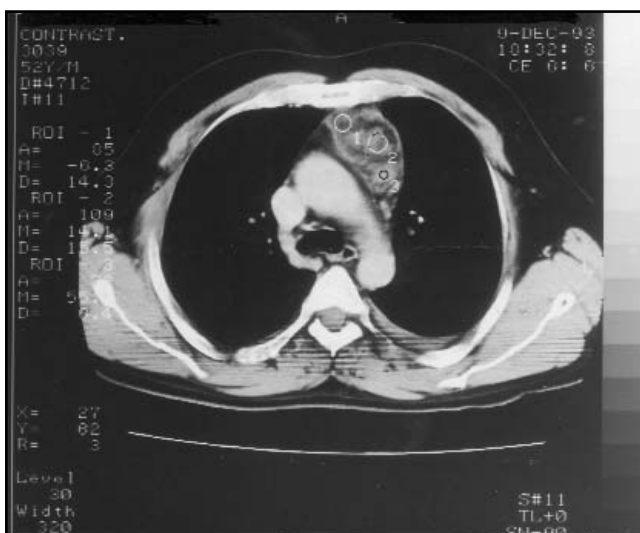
A CT Scan of the chest showing intrathymic parathyroid adenoma.
